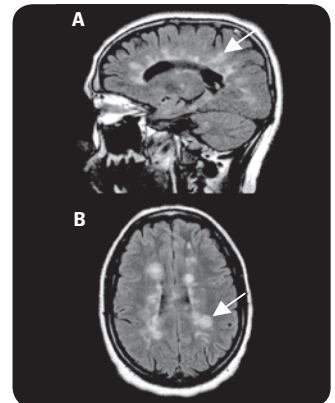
T2-weighted FLAIR: (A) sagittal (B) axial images of multiple sclerosis with periventricular “Dawson’s Fingers”
